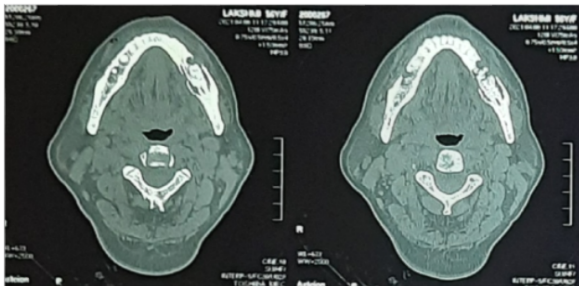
In axial CT - bone window shows sclerotic and lytic lesion evident in the left posterior mandibular region in relation to 36,37 region with perforation of buccal and lingual cortical plates-suggestive of ON
